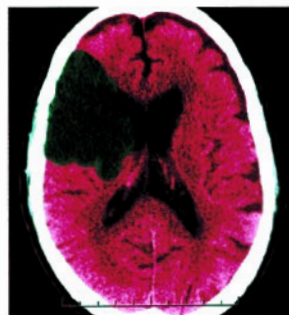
CT of MCA stroke
